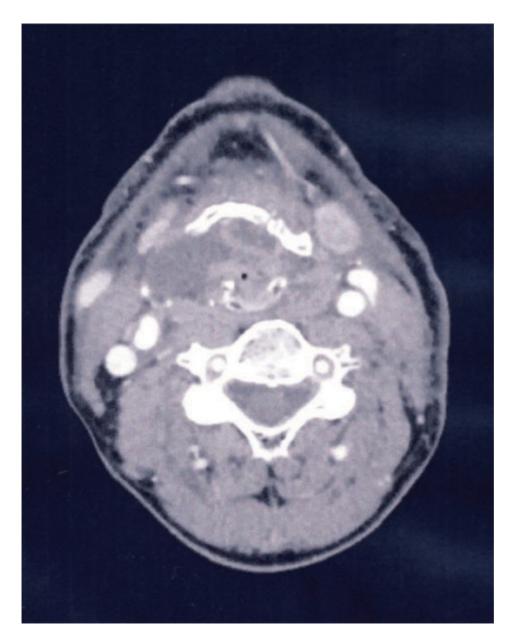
Computed tomography scan revealing a laryngocele associated with squamous cell carcinoma.
